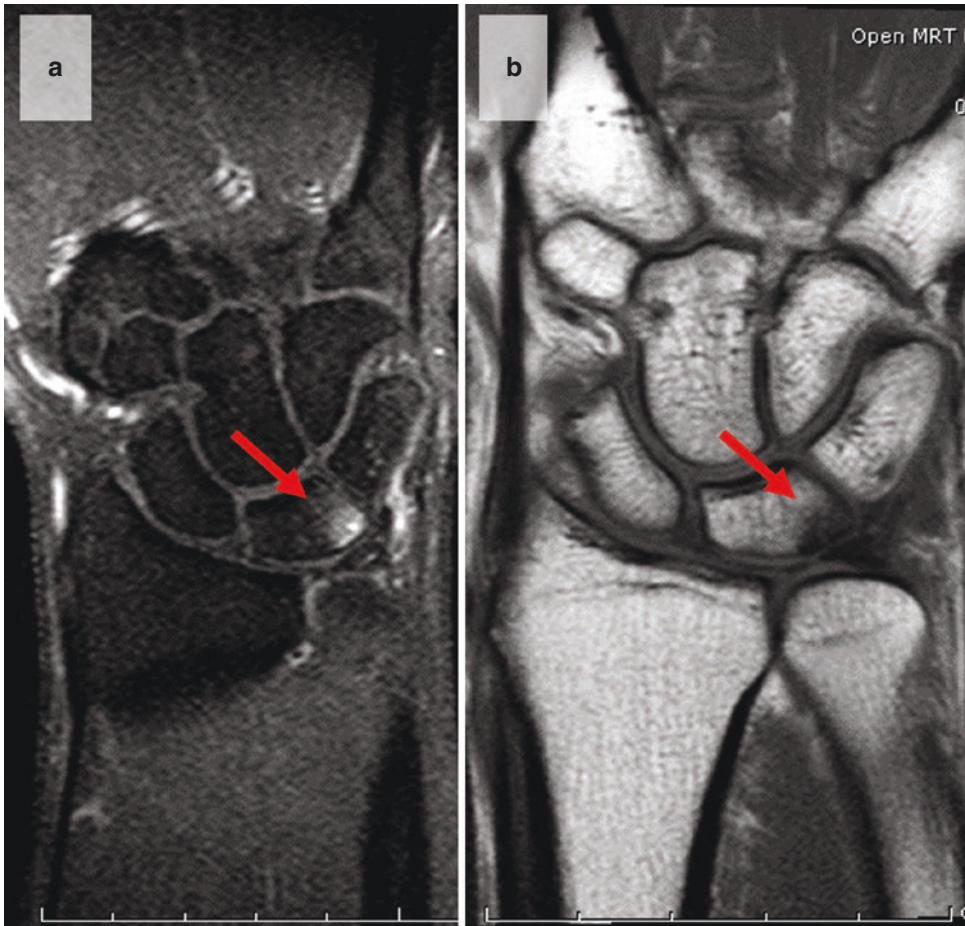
MRI of bone marrow edema within the lunate (a, T2 weighting; b, T1 weighting)
